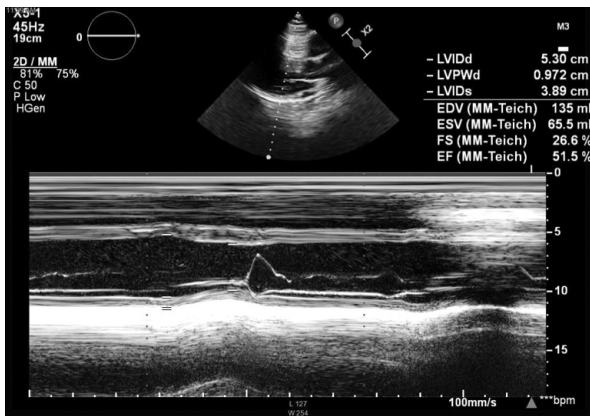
M-mode echocardiography. Parasternal line in the long axis. Reduced LVEF calculated by the Teichholz method (51.5%)
